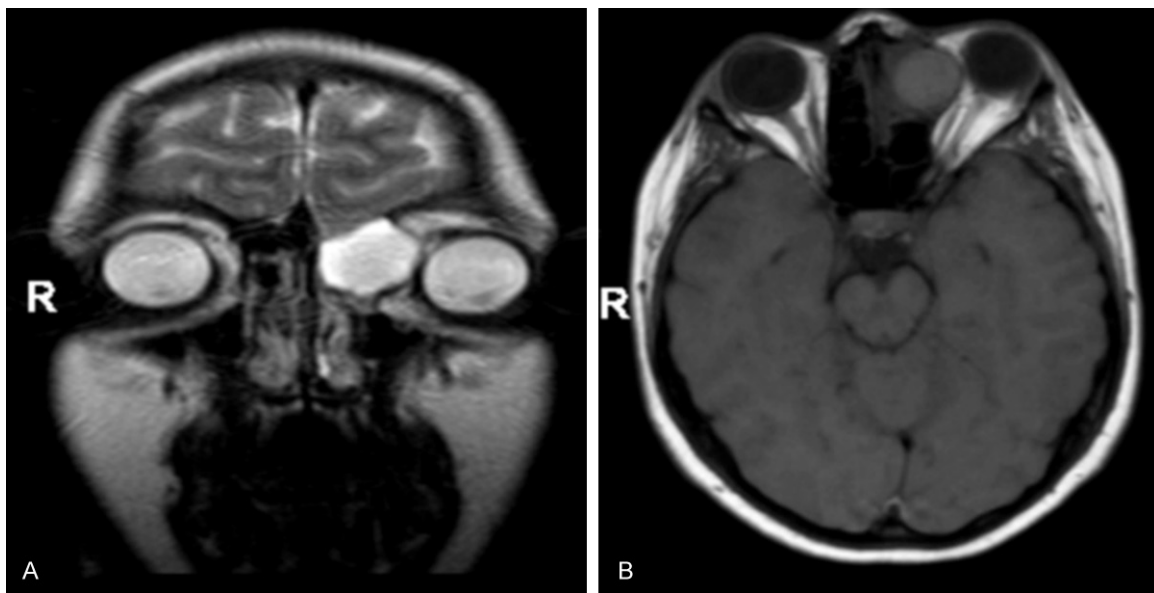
Magnetic Resonance images of ethmoid sinus mucocoele (A and B).
